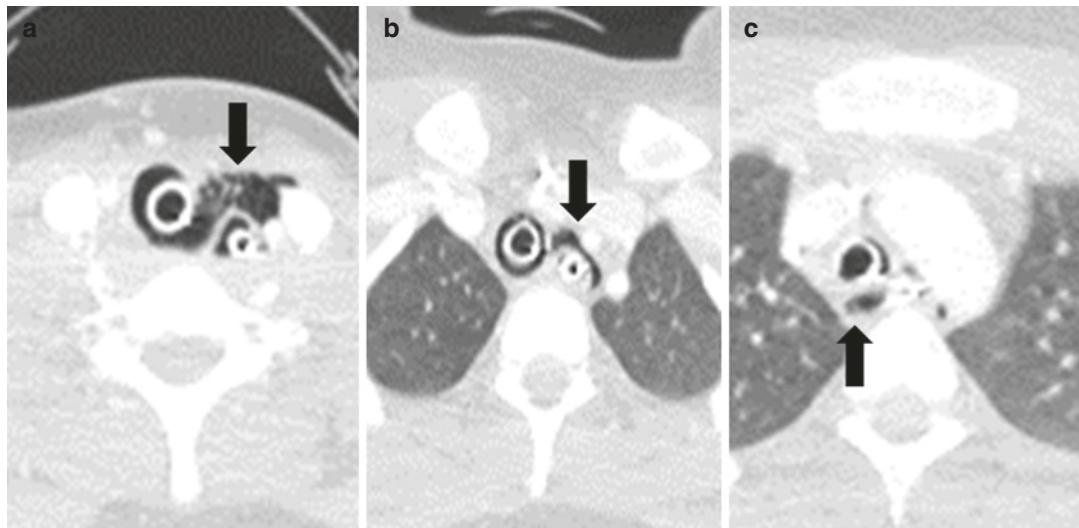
(a–c) Twenty-year-old woman presenting after MVC. Axial IV contrast-enhanced CT images of the upper thorax at different levels show tracheal injury (arrow). Tracheal injury was confirmed intraoperatively.
